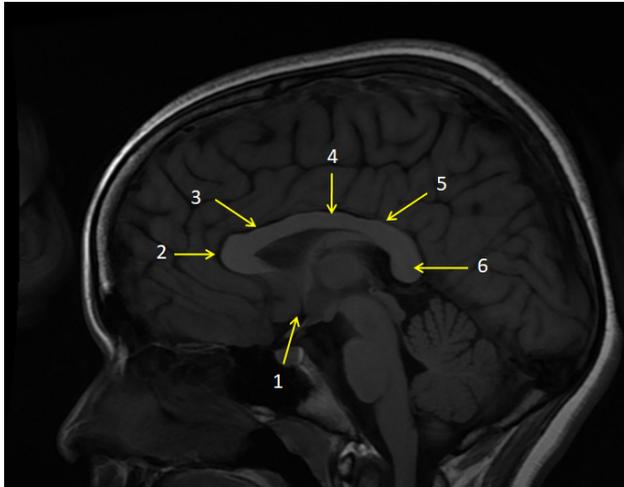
Mid sagittal T1 weighted image on 3T MRI shows normal segments of corpus callosum in 4 years old child in 1. Rostrum 2. Genu 3. Anterior body 4. Posterior body 5. Isthmus 6. Splenium
